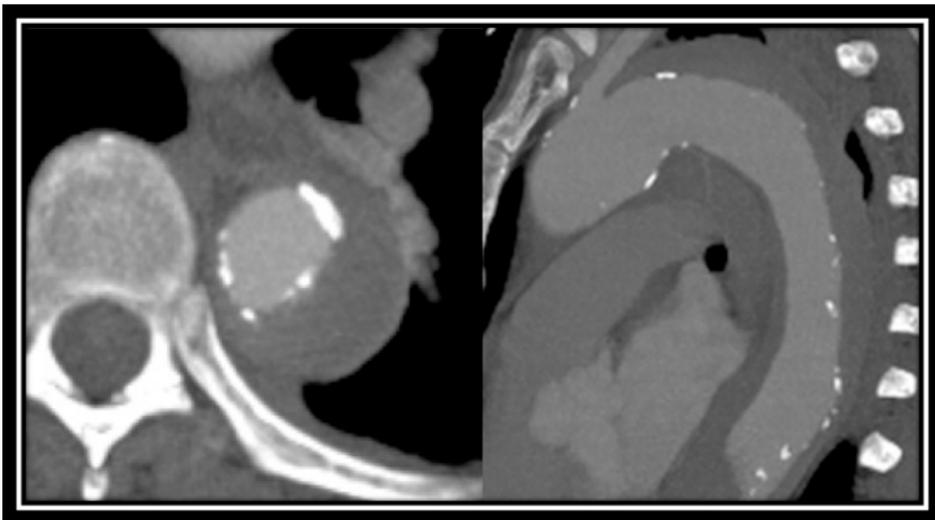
Computed tomography of intramural hematoma of the descending aorta. The hematoma takes a crescent shape surrounding the compressed true lumen with intimal calcification
